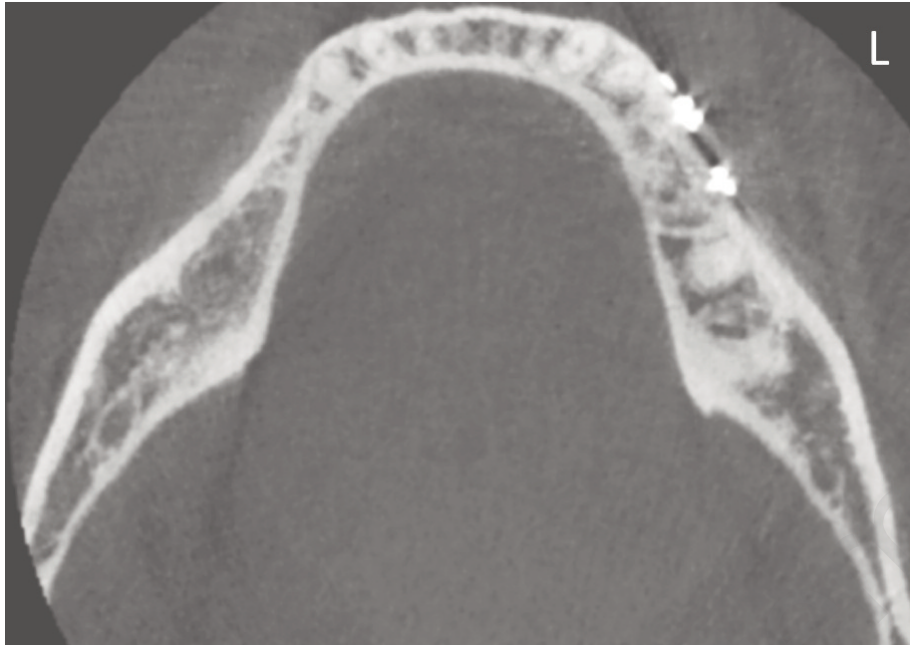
CT scan, axial view, 1 year after surgery. The bone lid is integrated and no residual bone defect is detectable. Fixation screws and miniplates are in place.
